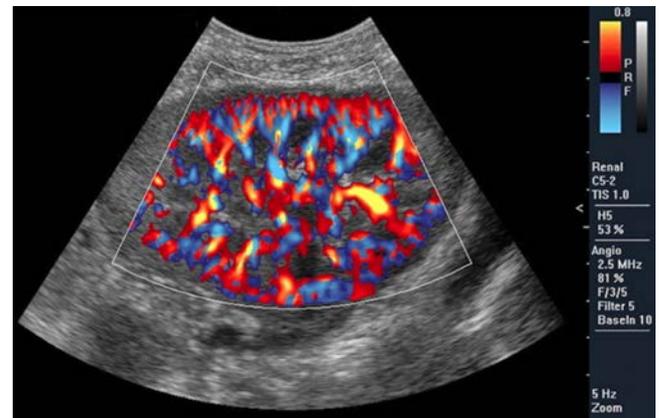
Directional power mode colour Doppler image showing the distribution of blood vessels in a transplant kidney.
